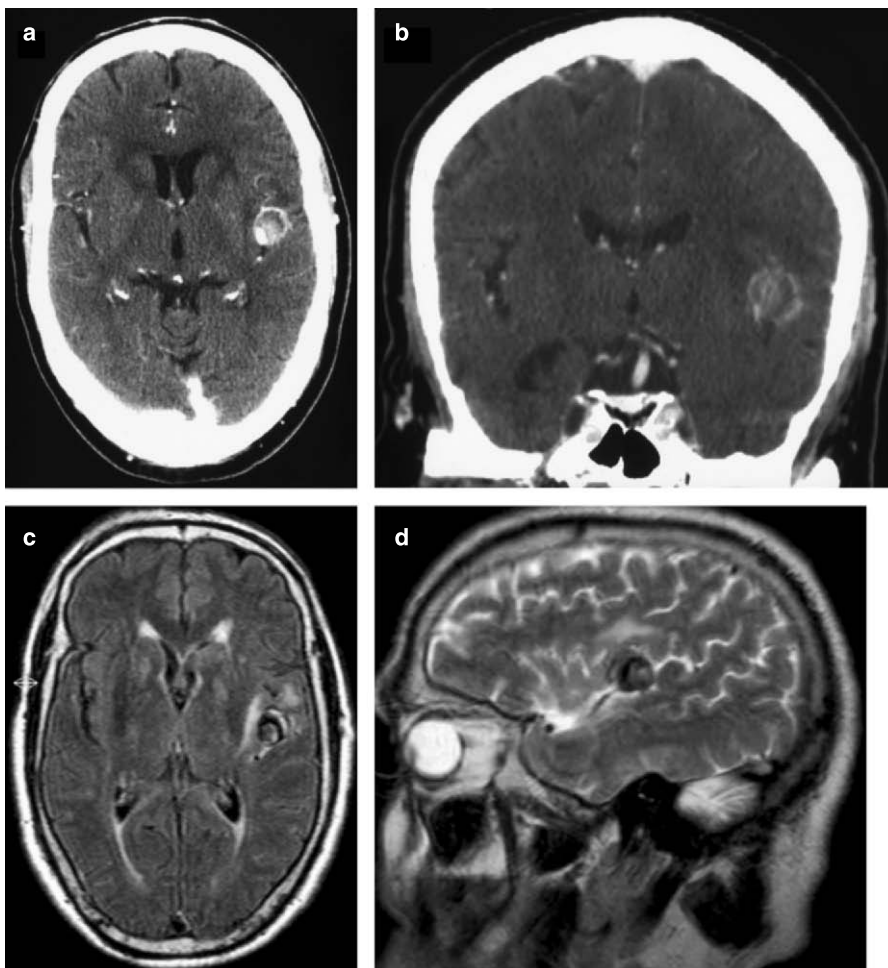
Case 1. Contrast-enhanced axial (a) and coronal view (b) CT demonstrating a 3 cm hyperdense lesion in the left Sylvian fissure. Noncontrast-enhanced FLAIR axial view (c) and T2-weighted sagittal view (d) MRI showing a giant left MCA aneurysm
